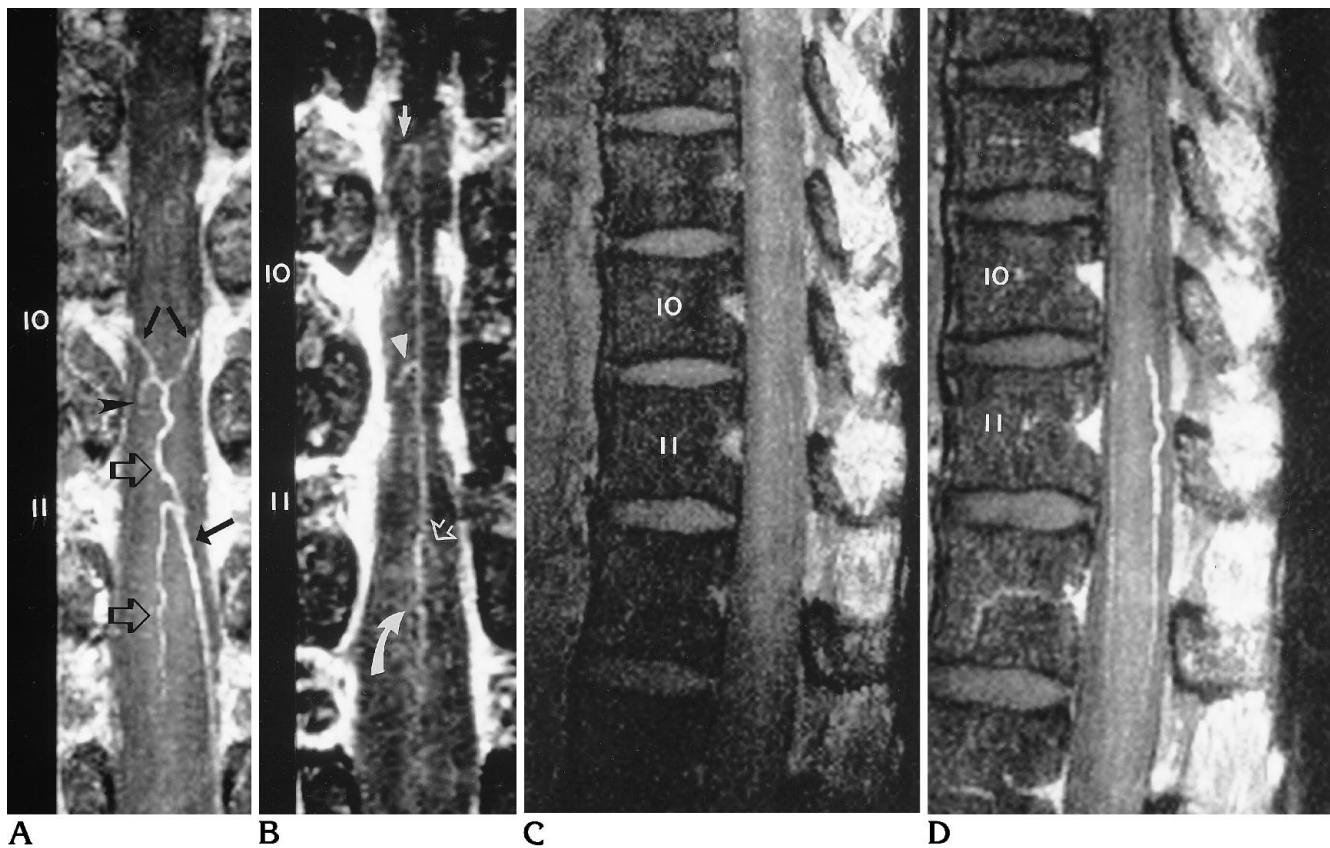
MR angiography and MR imaging in subject 3. Parts A, B, and D are produced from the same 3-D acquisition slab (sagittal orientation).
